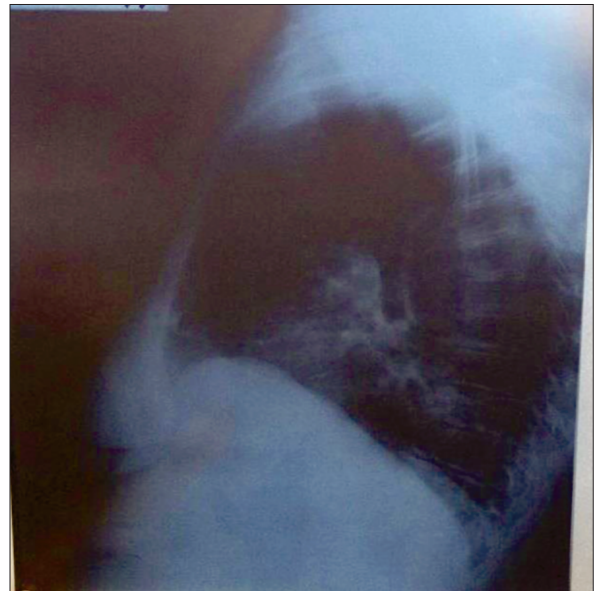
Chest X-ray, PA and LAT view. Opacity in the posterior basal segment of the left lower lobe and bilateral opaque subclavicular micronodules
